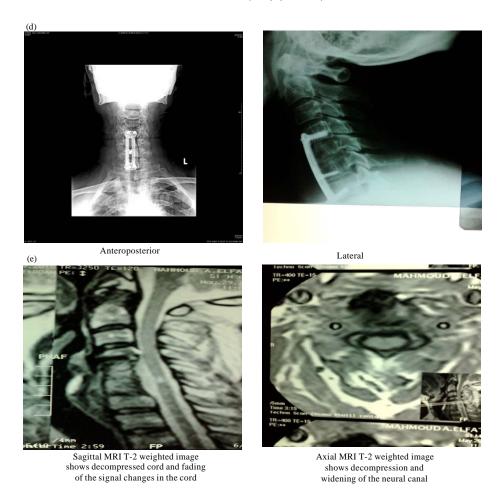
(a-e): Plain x-ray cervical spine antropesterior and lateral view demonstrated spondylotic changes with multiple ostephyte formation and narrowed (a) C 5-6, C6-7 spaces, (b) CT scan demonstrating segmental type of OPPL opposite C5 and C6 (c) MRI sagittal T2 WI and axial T2 WI shows large diffuse posterior prolapsed C5-6 markedly compressed cord and both related nerve roots (d) post-operative plain x ray AP and lateral view with internal fixation by plate from C4 to C7 and (e) post operative MRI axial and saggital T2 WI after 6 months shows decompressed cord and widening of the neural canal
